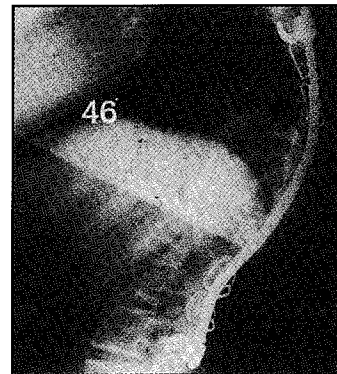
Lateral radiograph at maturity showing the sagittal curve further correcting to 46 degrees. This is due to continued anterior spinal growth in the presence of a solid posterior fusion.
